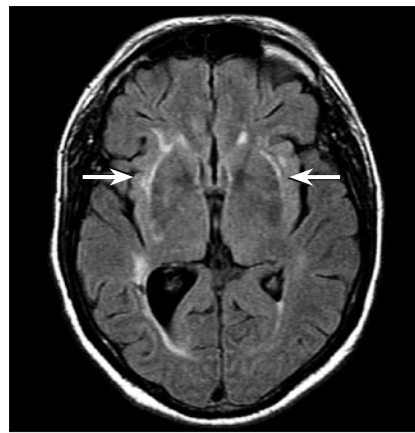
Axial FLAIR MR image reveals hyperintense signal of bilateral external capsules (arrows) and periventricular white matter.
